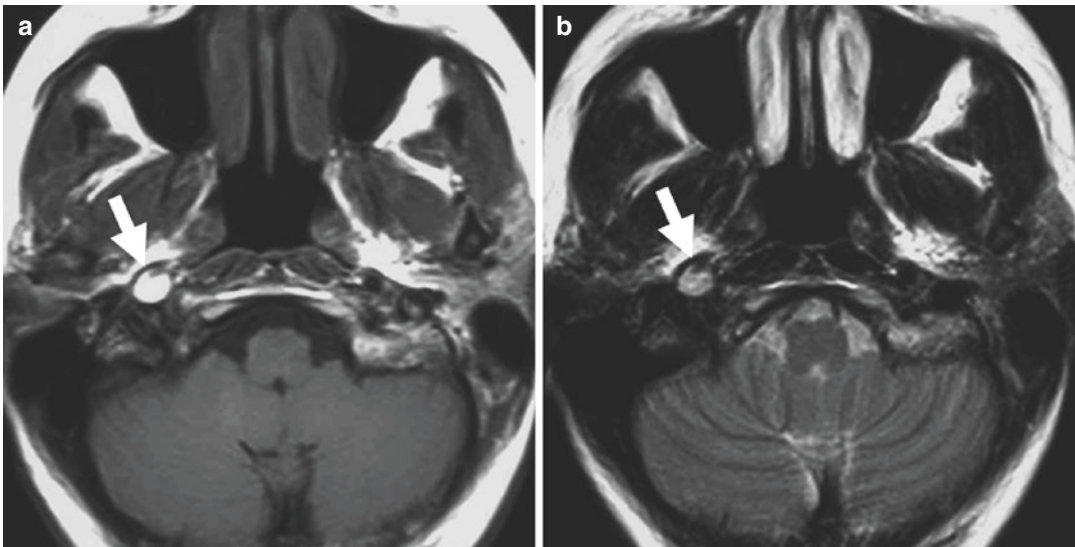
(a) T1-weighted axial section; (b) T2-weighted axial section; (c, d) 3D TOF MR angiography (MIP reconstructions). Internal carotid artery dissection demonstrated by the presence of a hyperintense intramural
